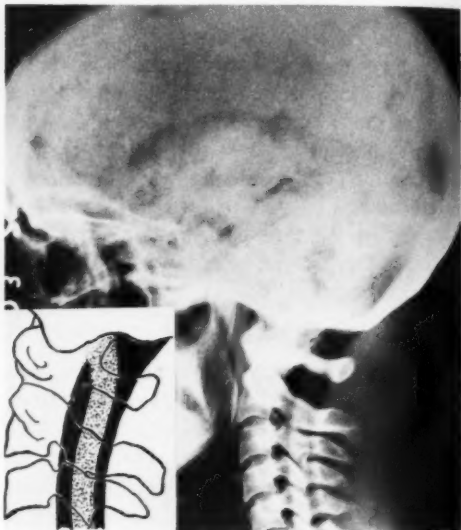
Upright lateral roentgenogram centered on cisterna magna. The normal cisterna magna and spinal cord are clearly outlined on this film.
